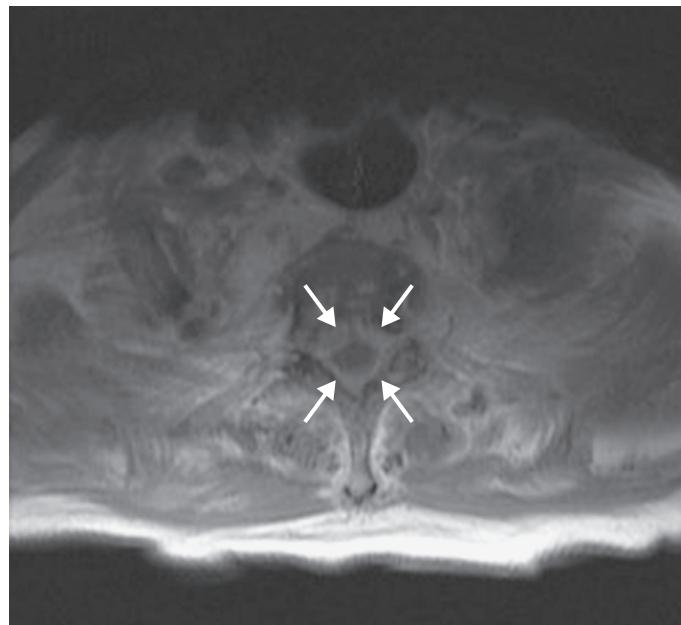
Postgadolinium T1 MRI showing circumferential epidural tumor around the thoracic spinal cord from esophageal cancer.
